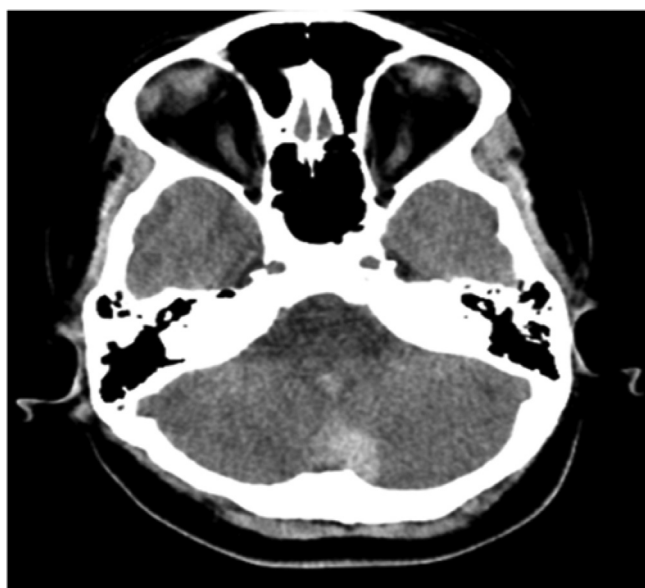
CT scan (axial view) shows cerebellar bleed predominantly in the region of the cerebellar vermis.
